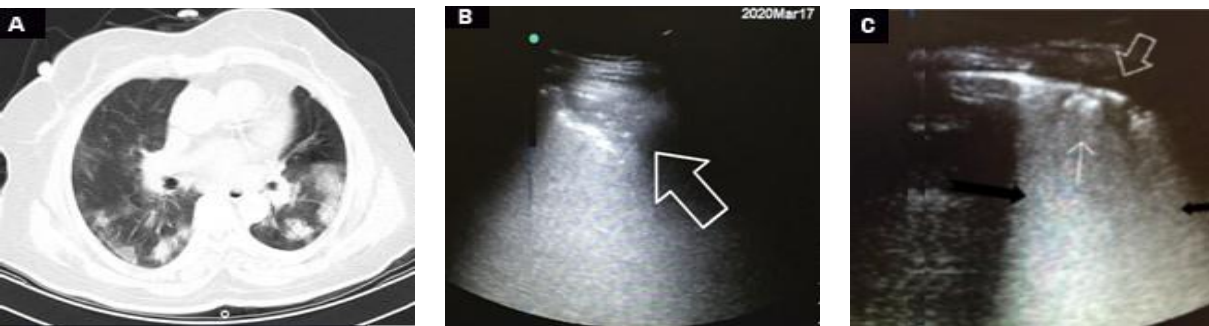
(A) CT scan shows consolidation and GGO in the apical segment of both lobes. (B) US of same region shows the consolidation. (C) US of small consolidation (thin arrow), B₂ lines (thick arrows), and adjacent pleural thickening (hollow arrow). GGO: Ground Glass Opacity.
